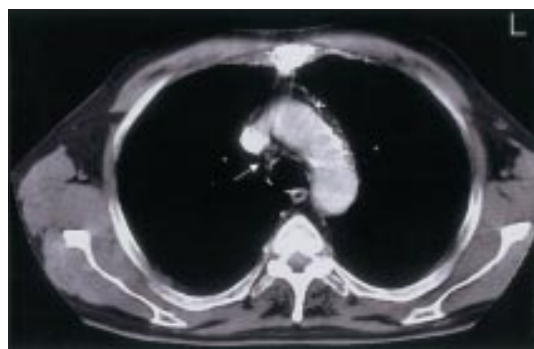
Computed tomography (CT) and positron emission tomography (PET) findings in a patient with squamous cell carcinoma of the right lung. Top: Level 2 CT. Centre and bottom: Axial and coronal PET respectively of area shown by arrow in CT. No abnormal mediastinal lymph nodes were seen on CT, but uptake of 2-deoxyglucose labelled with ¹⁸F was increased on PET (arrows). Reproduced with permission from Pieterman et al²⁴
